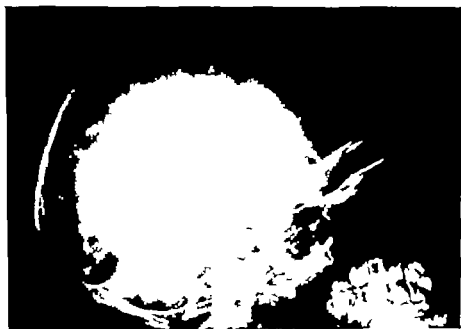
Roentgenogram of a circumscribed tumor in the right temporal bone of a 9-year-old girl which had slowly increased in size over a period of 2 years. It had provoked slight reactive sclerosis around most of its periphery. The tumor measured 3.5 cm. in its greatest dimension and 2.5 cm. in thickness and was found at surgical exploration to have expanded both tables of the calvarium. The patient was entirely well at the last follow-up 15 months after local excision. (From Lichtenstein, L.: Benign Osteoblastoma, *Cancer* 9: 1044, 1956.)
